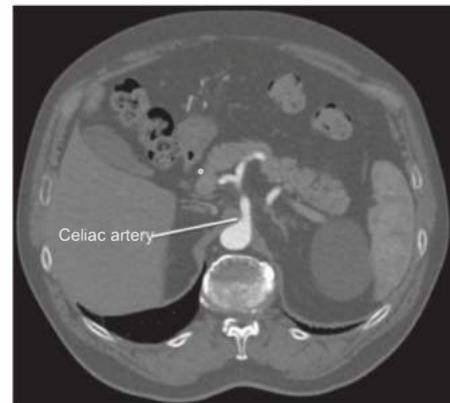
• Axial CT scan image shows a normal celiac artery origin.
